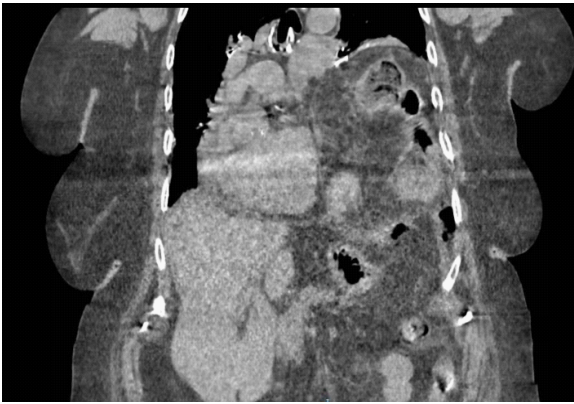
CT image showing a left Morgagni-Larrey hernia with gastric and colonic contents inside.
